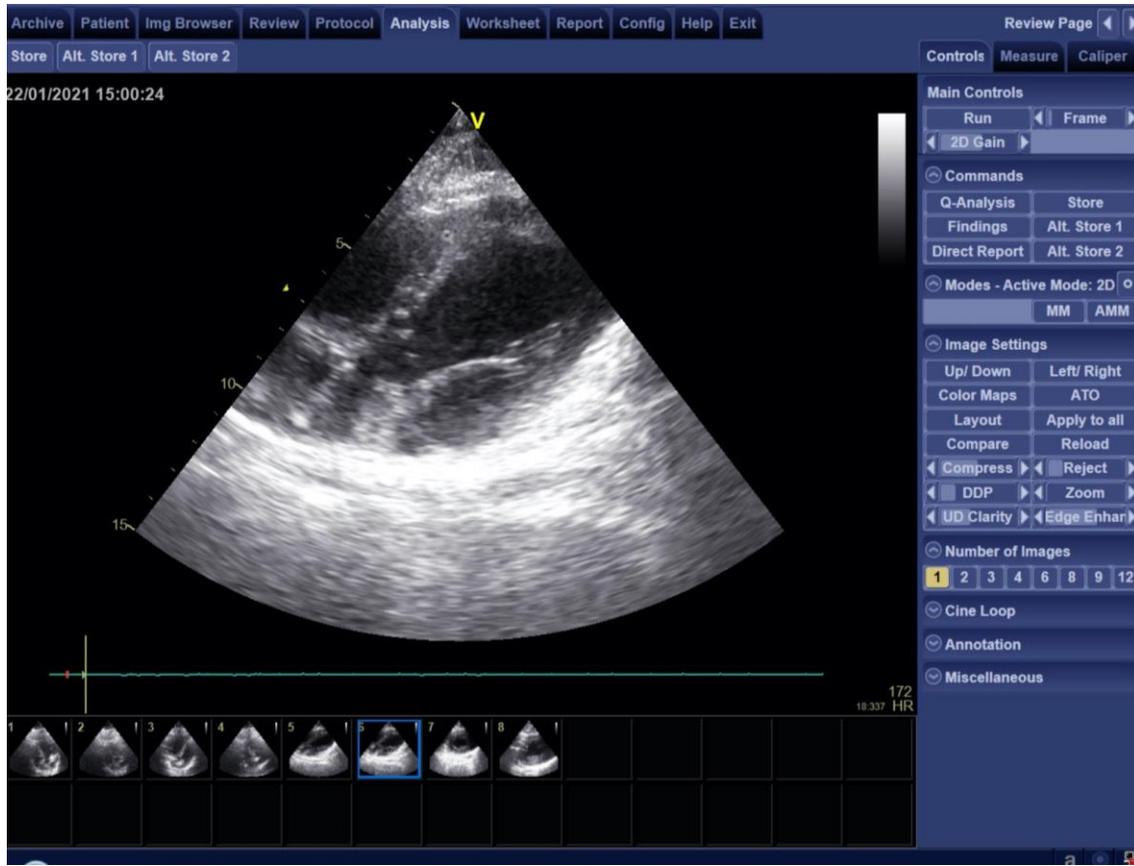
Parasternal long axis (PLAX) of the Left Ventricle (LV) and aortic valve, representative of the superior-inferior site of Standard Chest Compression (SCC).
